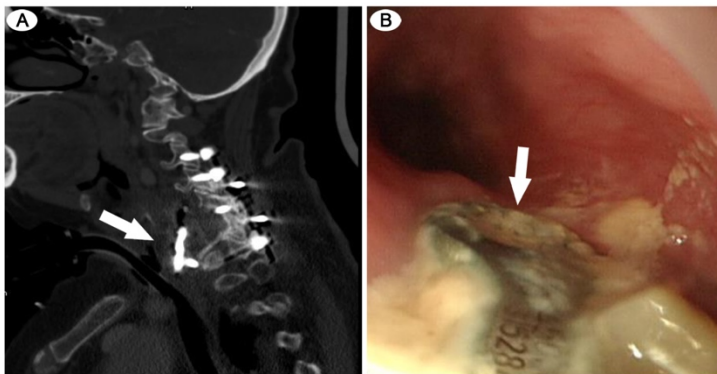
Computed tomography of the neck and esophagoduodenoscopy (A) Sagittal view showing anterior displacement of the fixation prosthesis (arrow). (B) A metal prosthesis with product code is visible in the esophagus (15 cm from the incisor), surrounded by ulcerative mucosa (arrow).
